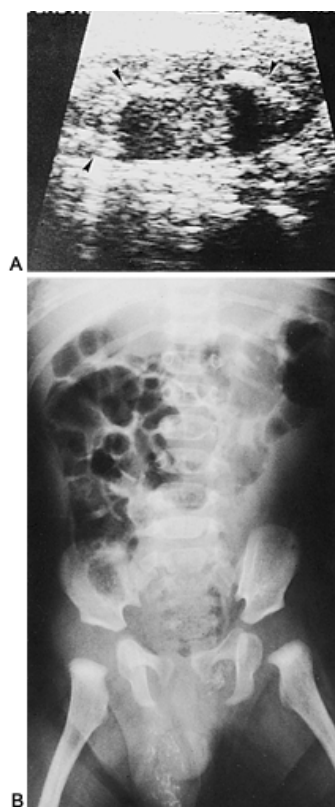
Meconium peritonitis and scrotal mass in a 4-month-old boy. A: Longitudinal sonogram of right hemiscrotum demonstrating multiple extratesticular echogenic foci (*arrows*) surrounding testis, suggesting calcification. B: Plain film indicating multiple calcified areas in scrotum and left inguinal canal along the processus vaginalis.
